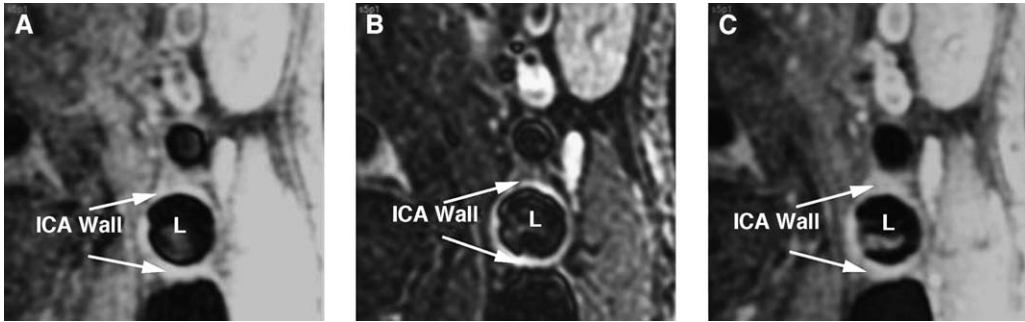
High-resolution MR images of the right carotid artery of a 75-year-old man with advanced atherosclerosis. (A) T2-weighted precontrast, (B) T1-weighted precontrast, and (C) T1-weighted postcontrast FSE images of the right internal carotid artery (ICA) demonstrating only arterial wall remodeling caused by atherosclerotic plaque (arrows). Note the lipid core is absent. L, lumen.
